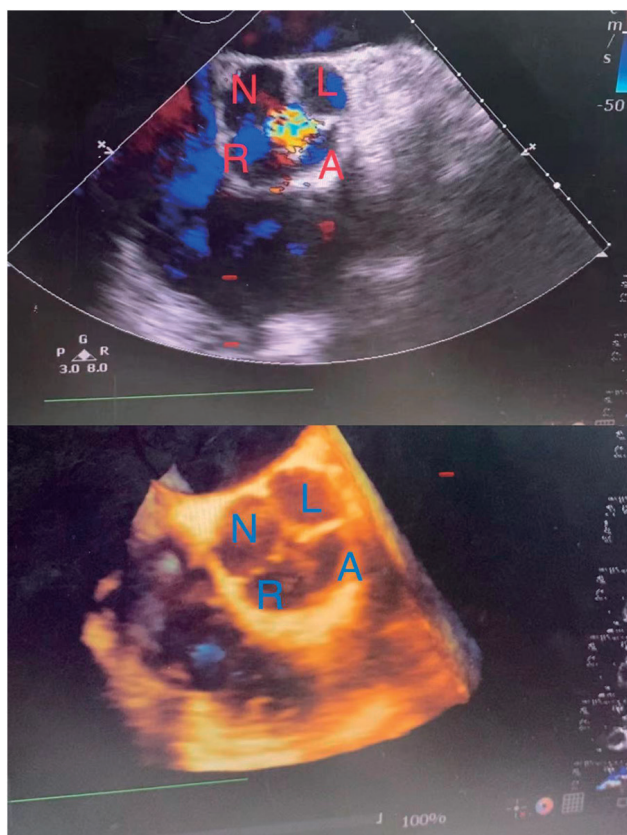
Preoperative TEE found QAV with an accessory cusp between the left and the right coronary cusps. TEE: transeophageal echocardiogram; QAV: quadricuspid aortic valve
